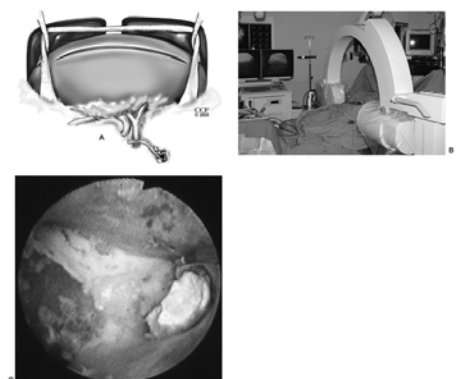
A: Intraoperative organ films had been a standard part of the procedure to exclude the presence of residual fragments. In general, such static radiography has been replaced with more contemporary adjunctive techniques such as intraoperative real-time fluoroscopy, ultrasound, or pyeloscopy. B: Intraoperative fluoroscopy has become a standard part of these stone procedures to exclude the presence of residual fragments and to help locate them for removal. C: Residual calyceal stone identified during intraoperative flexible pyeloscopy.
